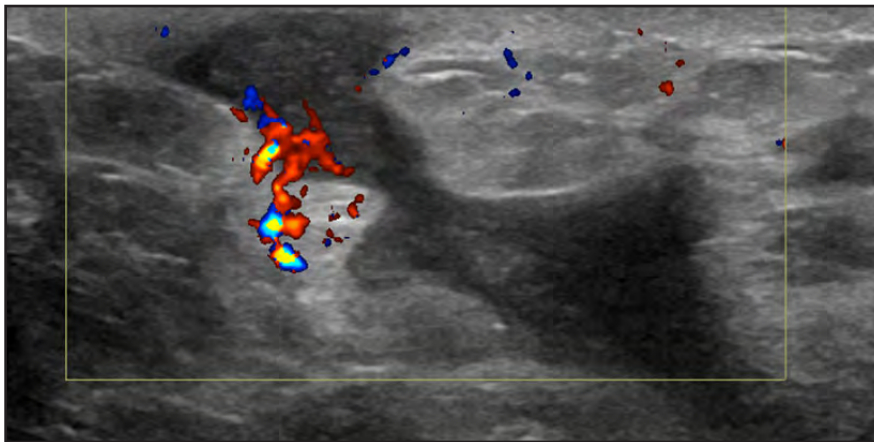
Targeted color Doppler ultrasound image at the site of concern demonstrates a hypoechoic fluid collection that insinuates throughout the fatty tissue with a tract that extends to the skin. Vessels in a rim are noted. No internal vascularity is appreciated.
